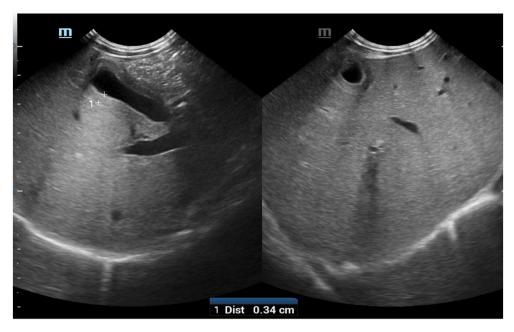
Ultrasound image of alithiasic cholecystitis.
